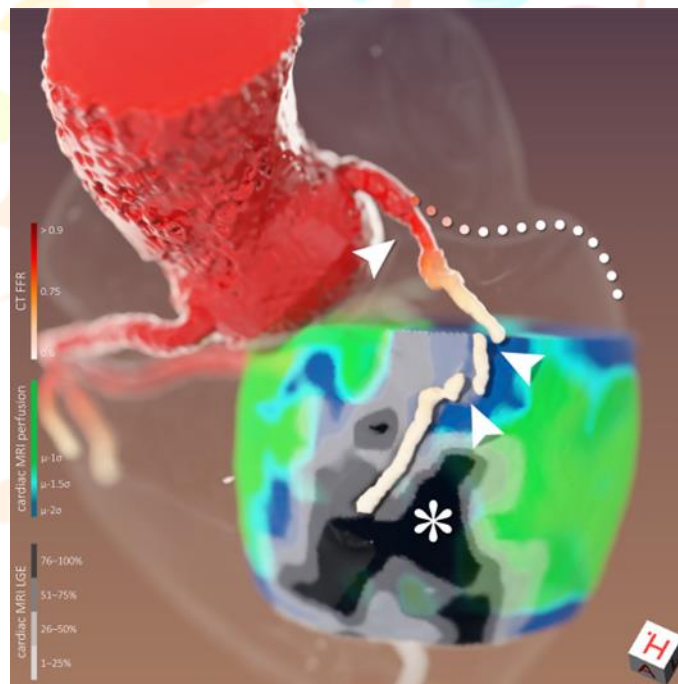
The visuals depict a 56-year-old male identified as patient 10. The images include both three-dimensional image fusion (referred to as 'a') and standard two-dimensional images (noted as 'b' for curved multiplanar CT coronary angiography reformation of the left anterior descending artery [LAD] and 'c' for cardiac MRI late gadolinium enhancement [LGE]). The images reveal several significant findings: there is a near-complete blockage in the proximal LAD, indicated by arrowheads in both 'a' and 'b', leading to decreased blood flow in the surrounding area. However, the viability of the myocardium remains relatively intact in the nearby region (with scar transmuralities less than or equal to 50%). Conversely, a complete blockage in the distal LAD has resulted in a large area of extensive scar tissue formation in the distal region, denoted by '*' in 'a' and 'c'. Additionally, due to a narrowing in the proximal left circumflex artery (LCx), the segmentation algorithm failed to accurately map its path, as shown by the dotted line in 'a'. Nonetheless, it is evident that the reduced blood flow in the LCx is leading to decreased perfusion in the lateral wall of the heart, although widespread scarring has not yet occurred. The text also mentions the CT-derived fractional flow reserve (CT FFR).
